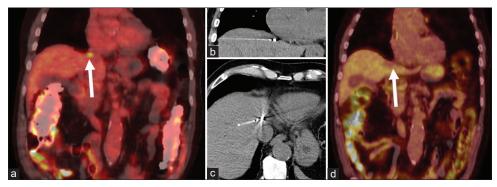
A 67-year-old male with alcoholic cirrhosis found to have LIRADS-5 lesion in hepatic segment VIII. (a) Pre-procedure coronal PET – computed tomography (CT) shows 1 cm increased FDG uptake in segment VIII near the heart (arrow). (b) CT-guided microwave ablation ablation of the tumor. The antenna tip abuts the diaphragm just under the heart. (c) Post-ablation 1-month follow-up PET-CT shows no more FDG uptake within the lesion (arrow).
